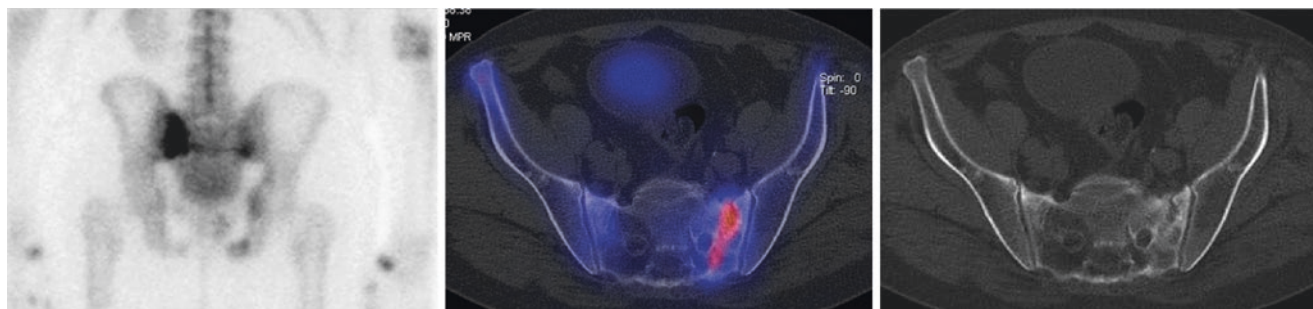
Bone scintigraphy performed in an elderly patient with long-standing pelvic pain. Dorsal planar view (left panel) shows zones with markedly increased tracer uptake in/near both iliosacral joints, connected by a thin line of increased tracer accumulation, the so-called
